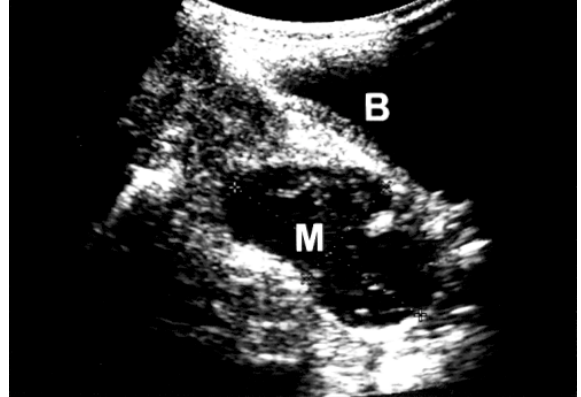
Appendiceal abscess. Longitudinal sonogram of the pelvis demonstrating a complex mass (M), posterior to the bladder (B), secondary to a ruptured appendix.
